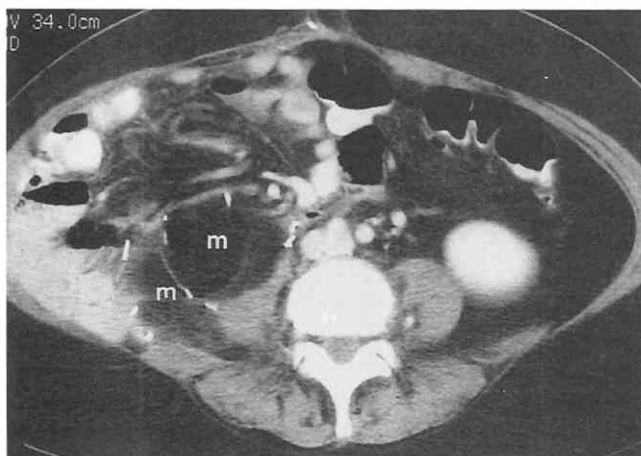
Recurrent liposarcoma. Contrast-enhanced CT scan demonstrates recurrences of a liposarcoma (m) in the right hemiabdomen of a 57-year-old woman 5 years after the initial resection. Surgical clips from the previous resection surround the tumors. The recurrent tumors have an attenuation similar to that of uninvolved adjacent retroperitoneal fat. When liposarcoma recurrences are small, they can be difficult to identify for this reason.
